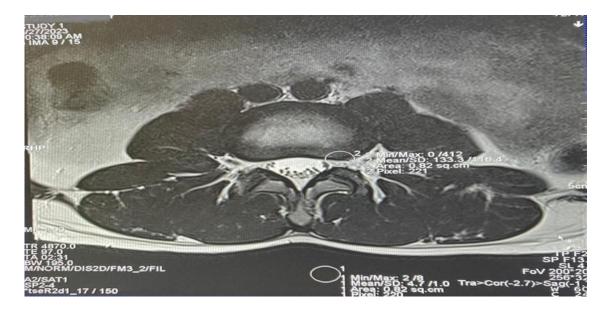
The ROnol Statistics on the MR image for a specific area of the lumbar spine to calculate SNR
